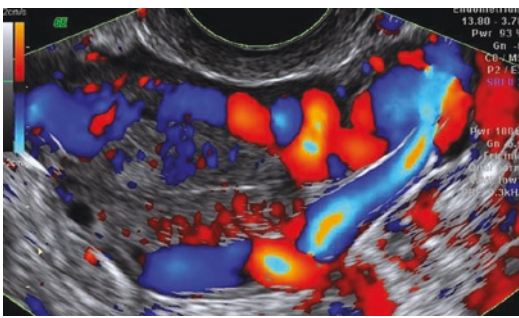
Color Doppler image of a transverse section of the uterus: the parametrial as well as the arcuate vessels are prominent. Some of the radial arteries are also detectable (the arterial blood in the anterior uterine wall, near the probe, flows away from the probe and appears blue, whereas the direction of the arterial flow in the posterior wall is toward the probe and appears red)
